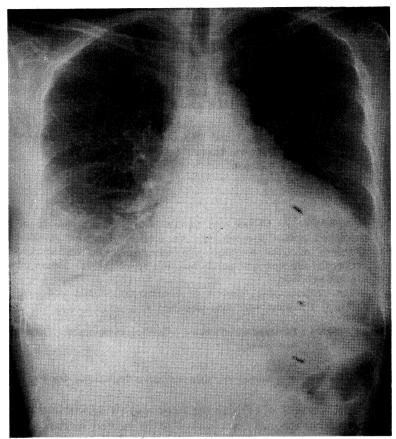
Chest X-ray film on admission demonstrating an enlargement of the cardiac silhouette, suggesting pericardial effusion and pleural effusion.
